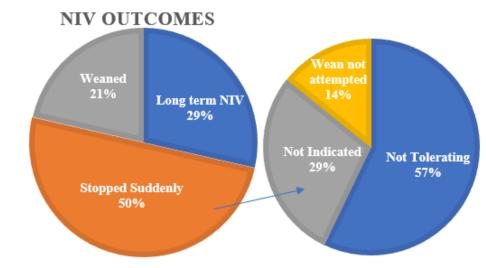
Outcomes of NIV and reasons for discontinuation in MRI audit 2024
